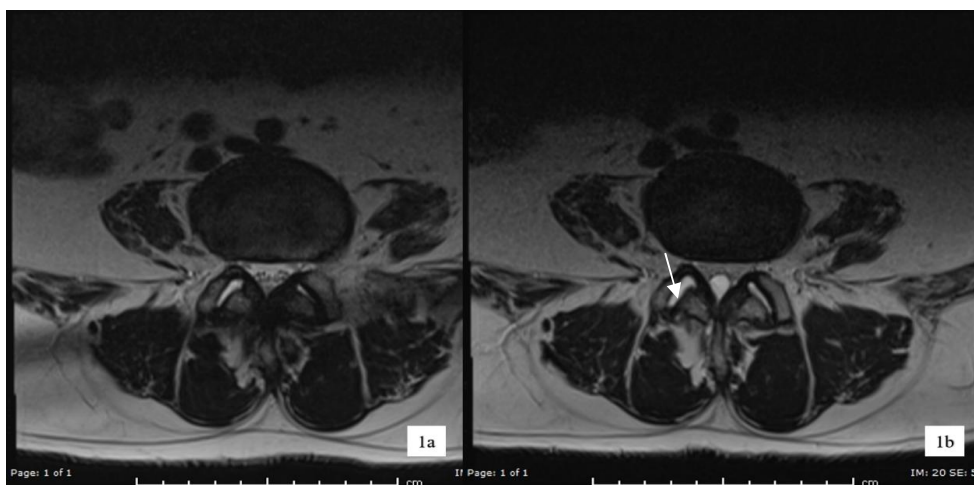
The first MRI showed mild spinal canal narrowing due to hypertrophies of both facet joints and ligamentum flavum (a) The second MRI revealed a droplet-like cyst of 9 mm in diameter (arrow) in the midline at the L4-5 intervertebral disc levels without any contact with facet joint (b)
